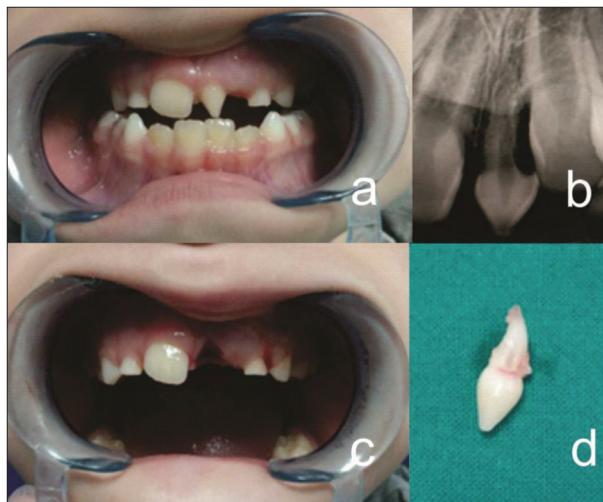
Erupted supernumerary tooth/mesiodens (a – clinical appearance, b – X-ray, c – extraction site, d – extracted mesiodens)
